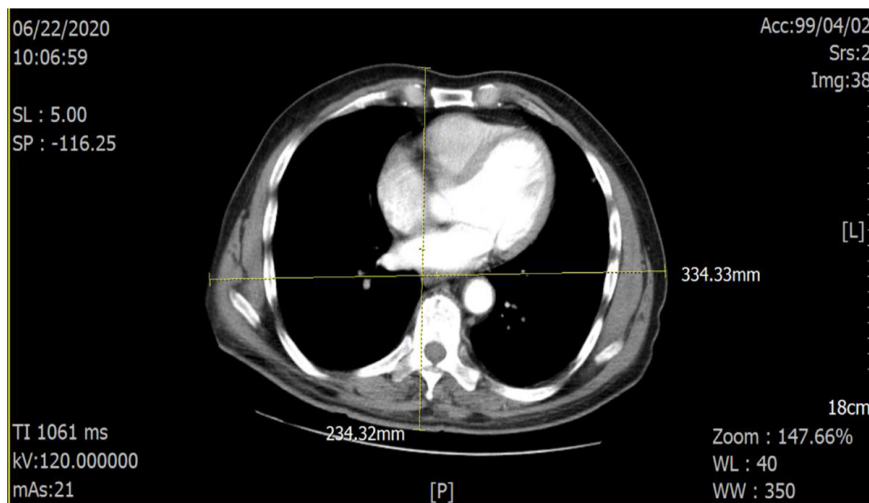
Measurements of the anteroposterior and lateral dimensions on the chest computed tomography (CT) scan images with contrast for the calculation of the patient effective diameter.
